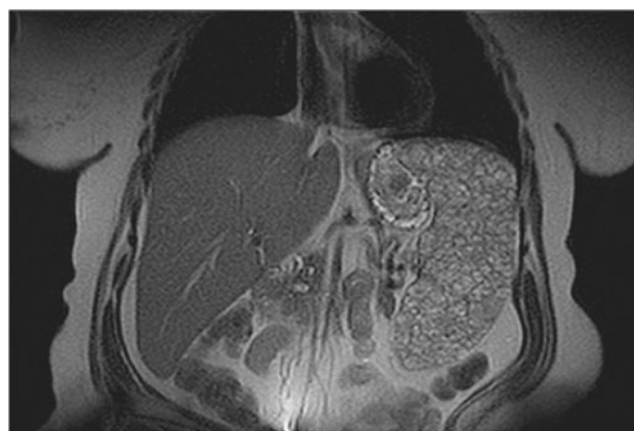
Abdominal MRI scan (T1- and T2-weighted sequences with contrast enhancement). The spleen is almost completely interspersed with multiple nodular lesions
